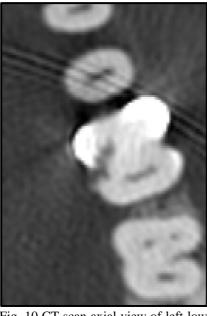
CT scan axial view of left lower first molar with cervical resorptions. The resorption can be seen in the lingual furcal area at the level of marginal bone. The perforation seemed to perforate into the pulp
